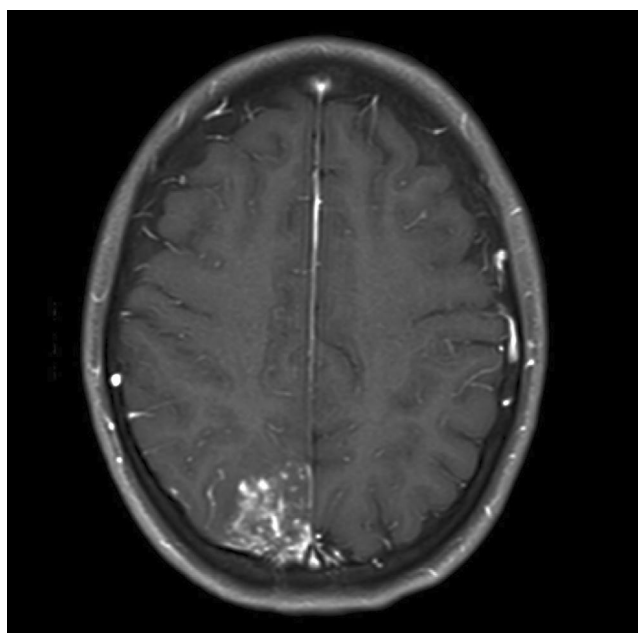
Brain MRI in axial T1-weighted post-contrast
